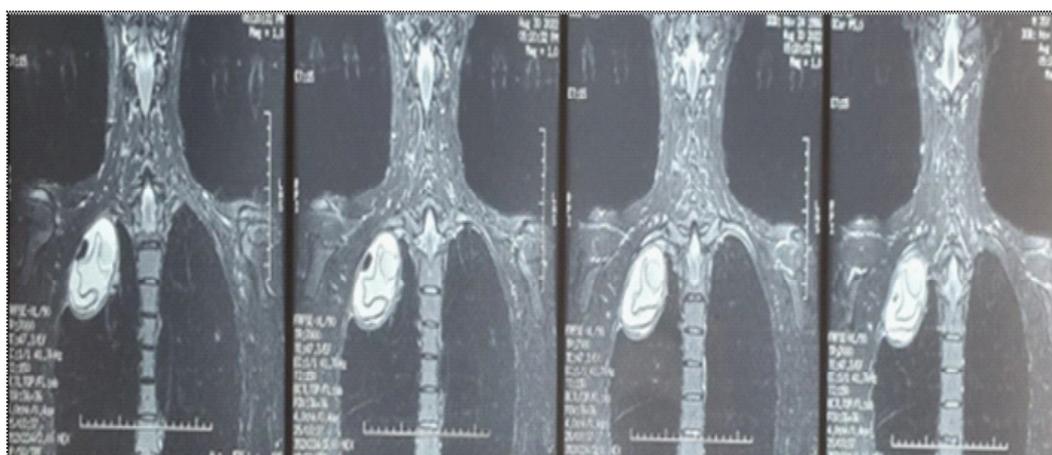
Cervico-thoracic MRI show casing right apex hydatidcysts compressing the brachial plexus.
